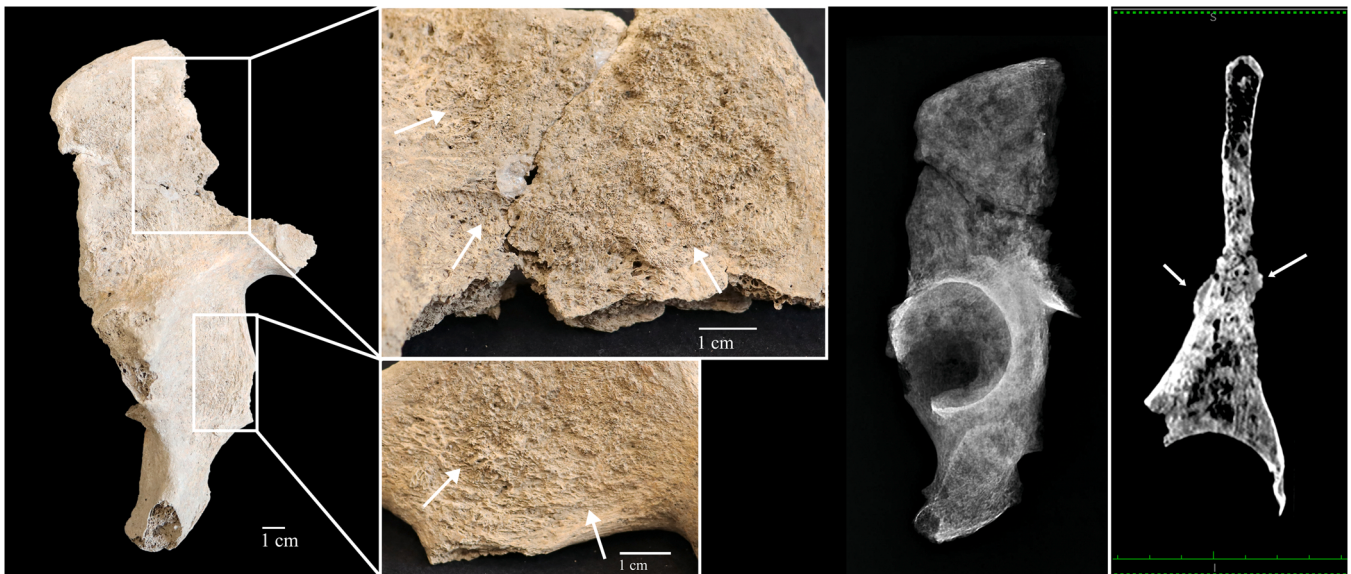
Right os coxae of individual US 7154, x-ray (medio-lateral orientation – middle) and coronal CT slice (lesions indicated with arrows – right) (conventional radiographs parameters: 70 kV, 2 mAs, 0.03 s, computed tomography parameters: exposure time= 15.67 s, scanning length= 481 mm, exposed range= 456 mm, and section thickness= 1.5 mm, with CT X-Ray source parameters of 100 kVp and 20 mA). Note the thick and spiculated new bone deposits on the cortical surface (white arrows).
